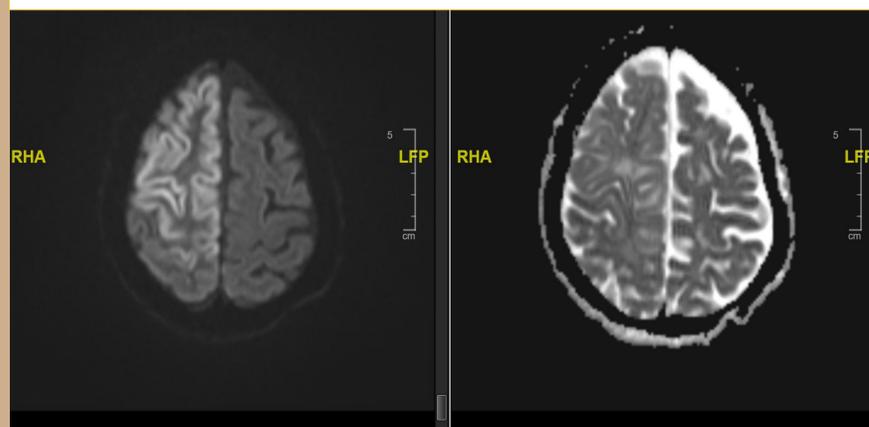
Initial MRI Brain with and without contrast, demonstrating an axial DWI image (on the left) showing restriction of diffusion in the right frontal lobe, with the associated ADC image (on the right) that demonstrates drop-out.
